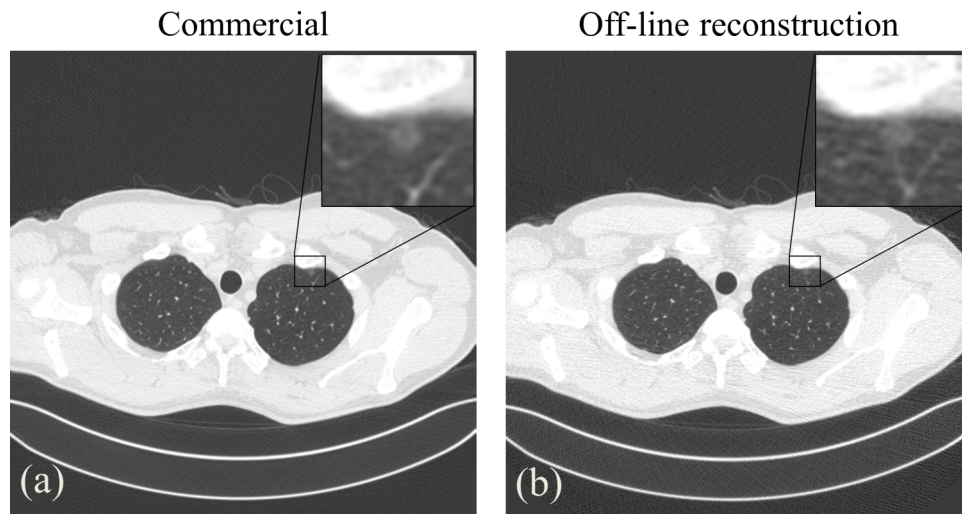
(a) A chest CT image reconstructed from commercial CT projection data using the scanner console. (b) A chest CT image reconstructed from DICOM-CT-PD projection data by an external researcher. The display window width is 1500 HU and the window level is -600 HU.
